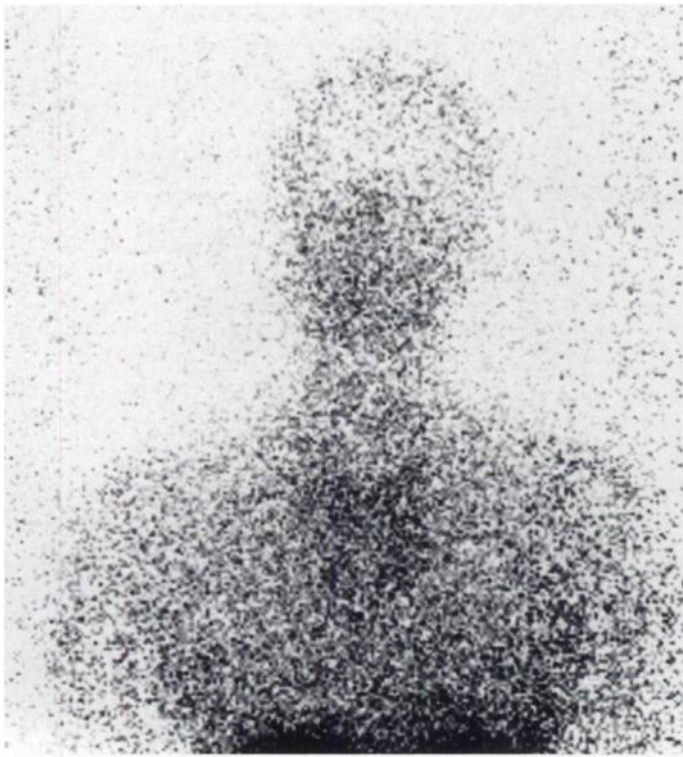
Somatostatin receptor scintigraphy anterior view of the neck and chest demonstrates diffuse mediastinal uptake in a patient who had previously received external irradiation to the neck and mediastinum.
